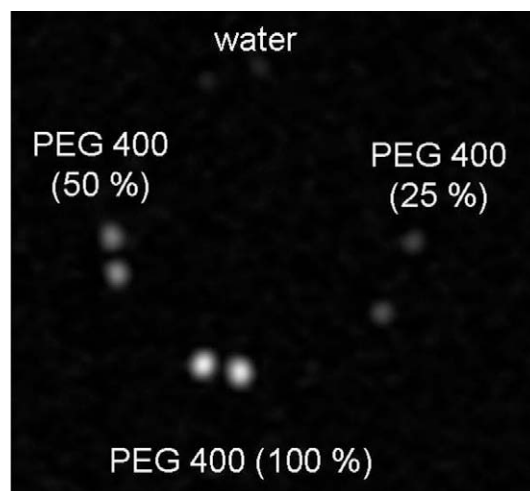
In vitro* MRI image of capillaries filled with different PEG 400–water mixtures showing the dependency of the MRI signal intensity on the PEG 400 content.
